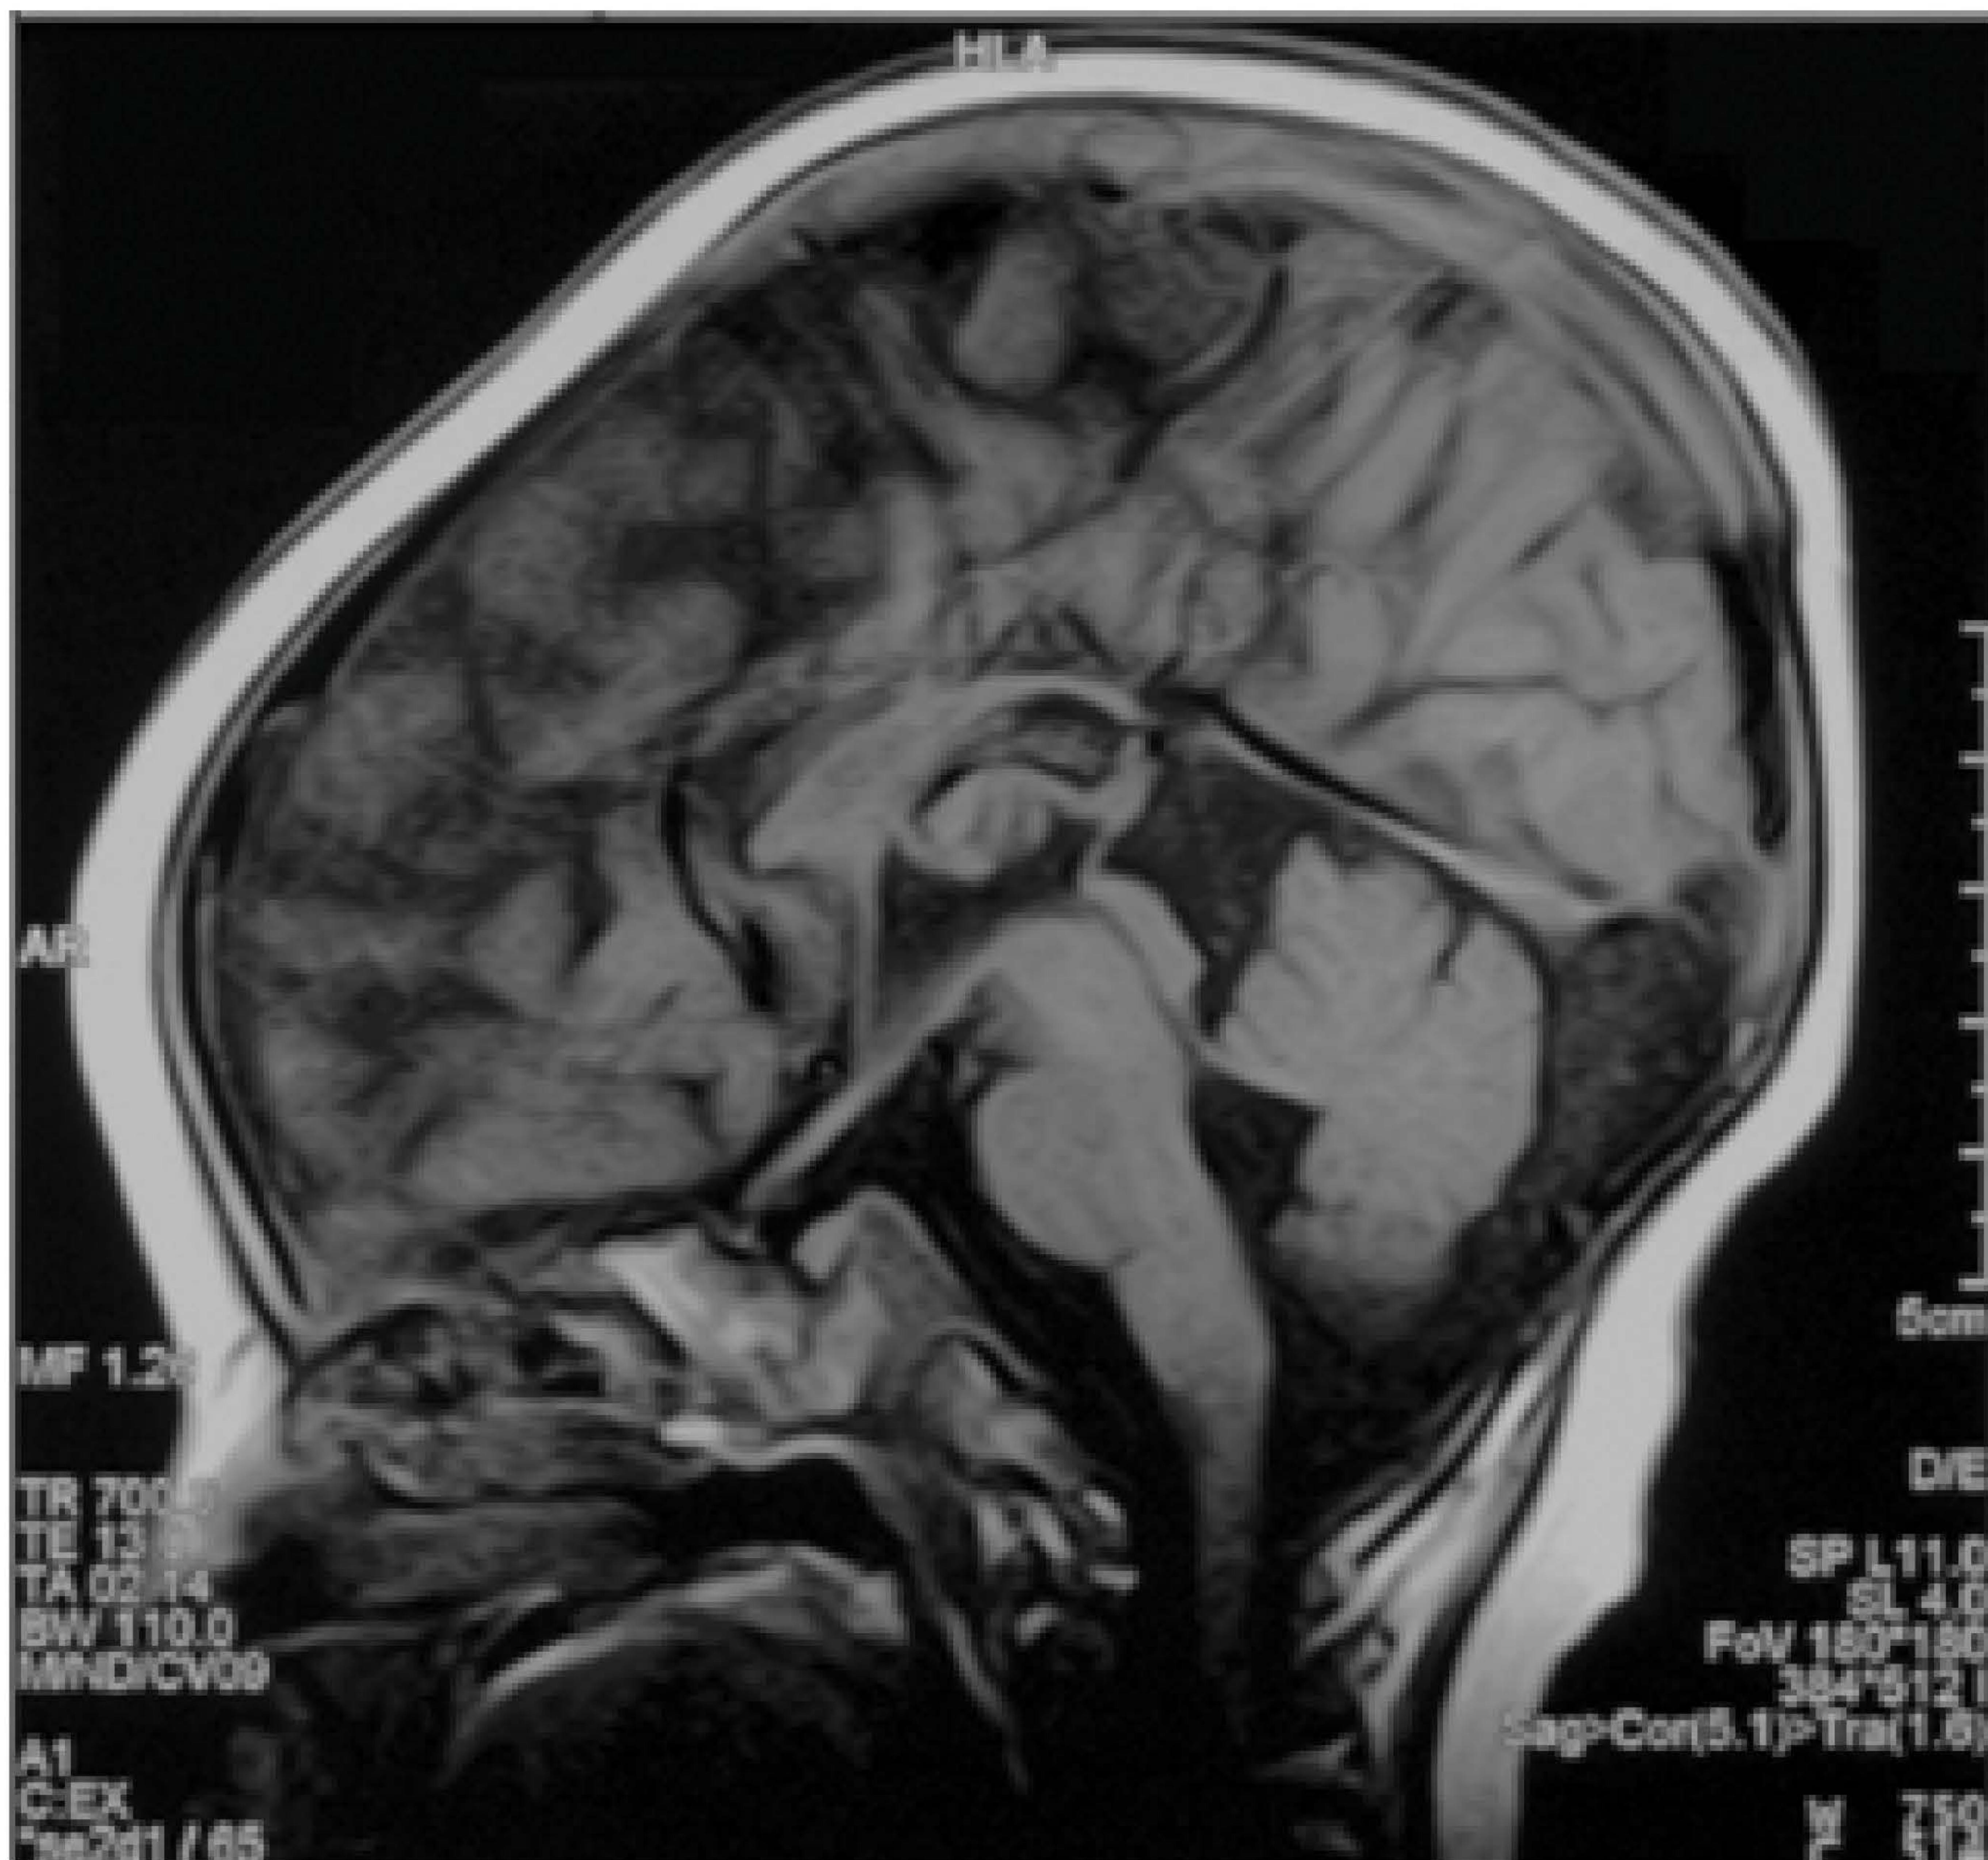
MRI showed slight thinning of the corpus callosum.
